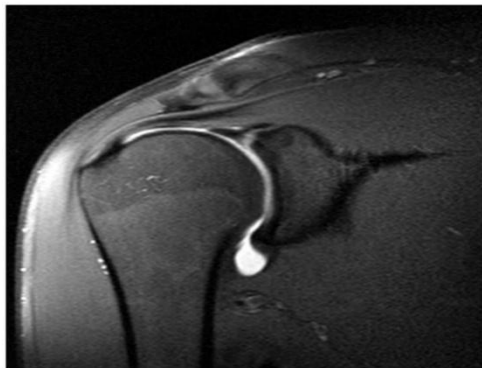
T1-weighted MR arthrographic image (Pouliart *et al.*, 2016)
